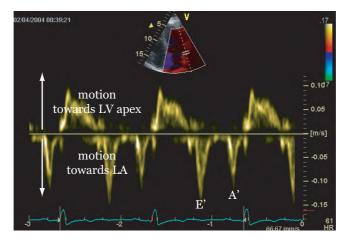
Typical biphasic tissue velocity profile during diastole recorded at the mitral annulus with tissue Doppler imaging (TDI). The tissue E'- and A'-waves correspond with the early and late transmitral flow velocities.
